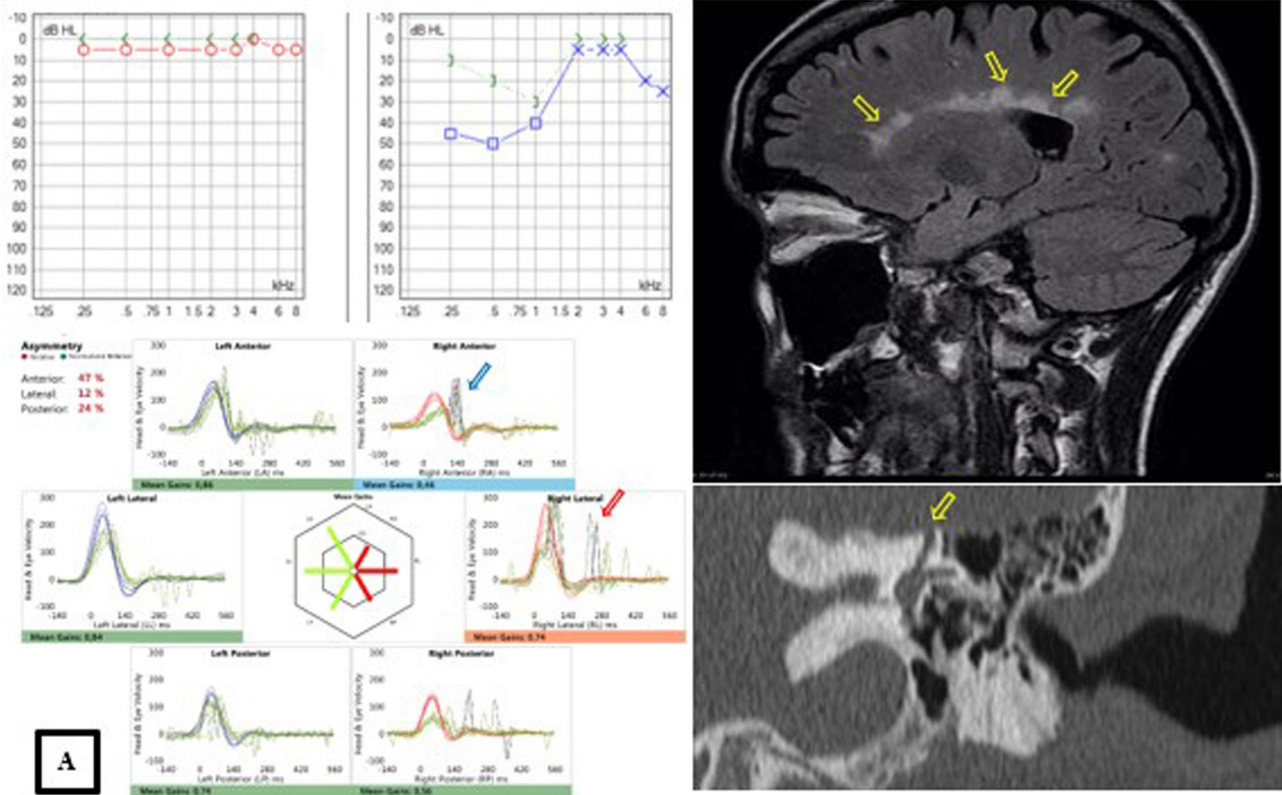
(A) Images of different diagnostic tests performed to make the diagnosis. The top left image shows the audiogram of a patient with Ménière disease of the left ear, with the characteristic pattern of low frequency hearing loss. The bottom left image corresponds to the vHIT of a patient with vestibulopathy of the right ear, with impaired function on the right side and presence of both covert (blue arrow) and overt (red arrow) saccades. The top right image shows an MRI scan of a patient with vertigo and hearing loss due to multiple sclerosis, with the characteristic feature of Dawson fingers (yellow arrows). Lastly, the bottom right image corresponds to a patient with third window syndrome due to superior semicircular canal dehiscence (yellow arrow). (B) Summary of the treatments used to manage the diseases of the patients in the cohort.
